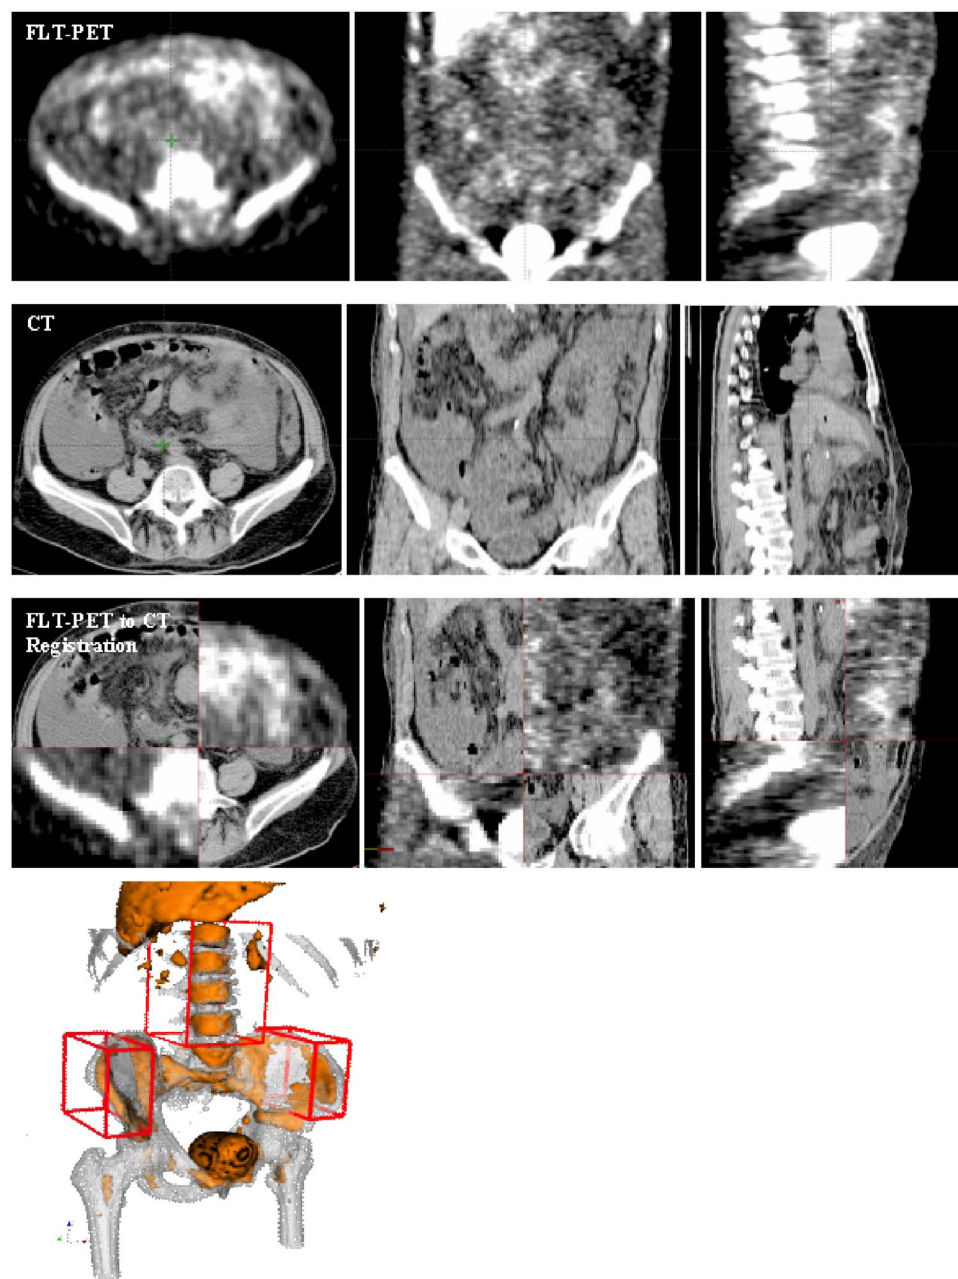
Screenshots of sagittal, coronal, and axial views of the FLT-PET images (first row) and CT images (second row). The checkerboard of the CT and FLT-PET images after registration is shown in the third row. The fourth row shows a stereotactic view of the matched PET and CT images after registration.
